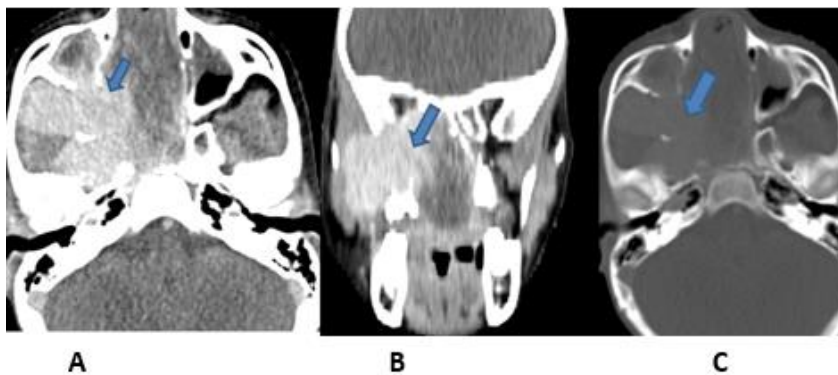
Post contrast Axial & coronal soft tissue (A&B) and axial bone window (C) CT of a 12 years old male who presented with epistaxis showing a large lobulated markedly enhancing mass lesion involving the region of the right sphenopalatine foramen expanding the right prerygopalatine fossa and extending along the pterygomaxillary fissure to the right infratemporal masticator space, filling the nasal cavity with nasal septal deviation to the left with obliterated bilateral nasal cavity, to the nasopharynx with obliteration of the nasopharyngeal airway. The mass also extends to the right maxillary, ethmoid and sphenoid sinuses. There is also intracranial extension (not shown).
